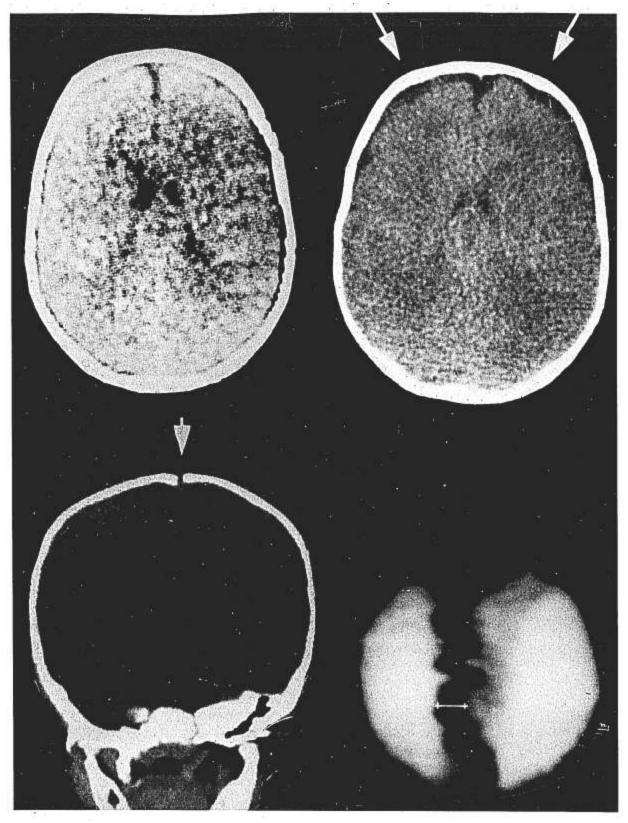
(Patient 1) (Top left) Normal initial CT scan. (Top right) Repeat scan, uninfused, day 5, indicates small lucent extra-axial collections (arrows) in frontal regions. (Bottom left) Coronal uninfused scan shows small subdural collection over convexity. Notice lucent subdural collection outlining sagittal sinus in negative relief (arrow), as well as lucent interhemispheric subdural collection. (Bottom right) Bone window scan shows split sagittal suture. (Normal <0.2 cm)
